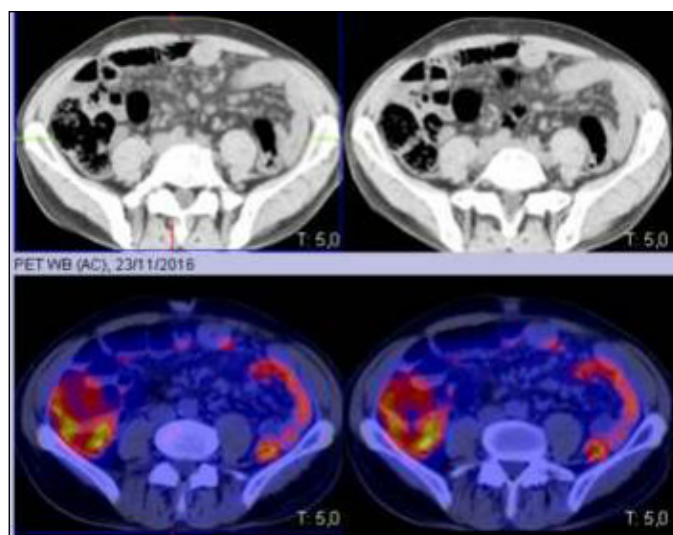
PET-CT scan performed in 2016 described the presence of retroperitoneal and mesenteric non-catching adenopathies, without being able to rule out the possibility of indolent mature lymphoid neoplastic involvement.
